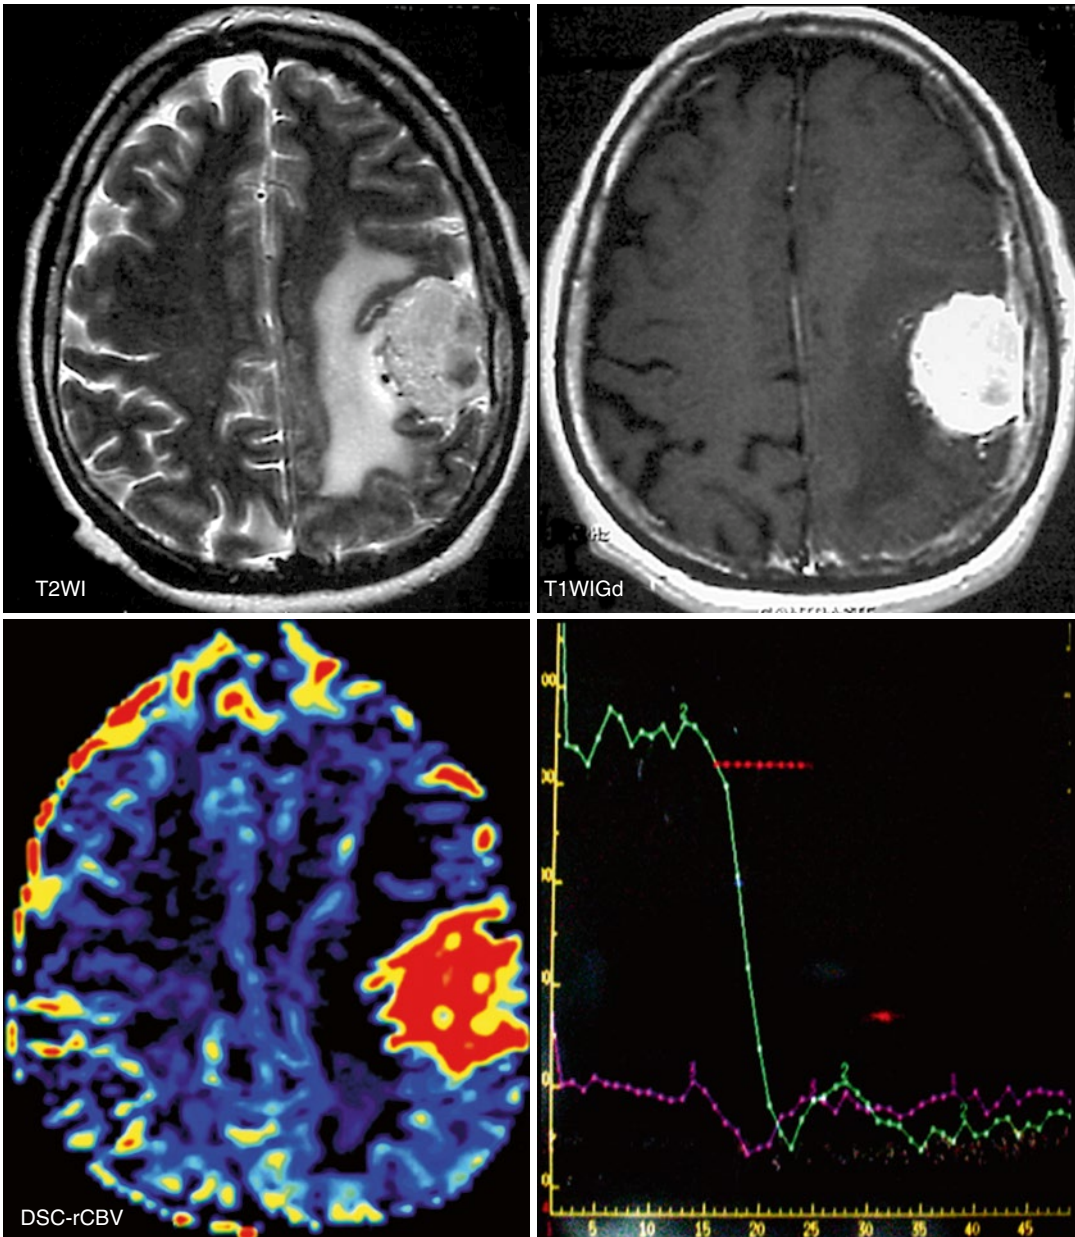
Atypical meningioma in a 52-year-old man that presented with headache and right hemiplegia. DSC-MRI shows a high rCBV value of this lesion. The TIC
